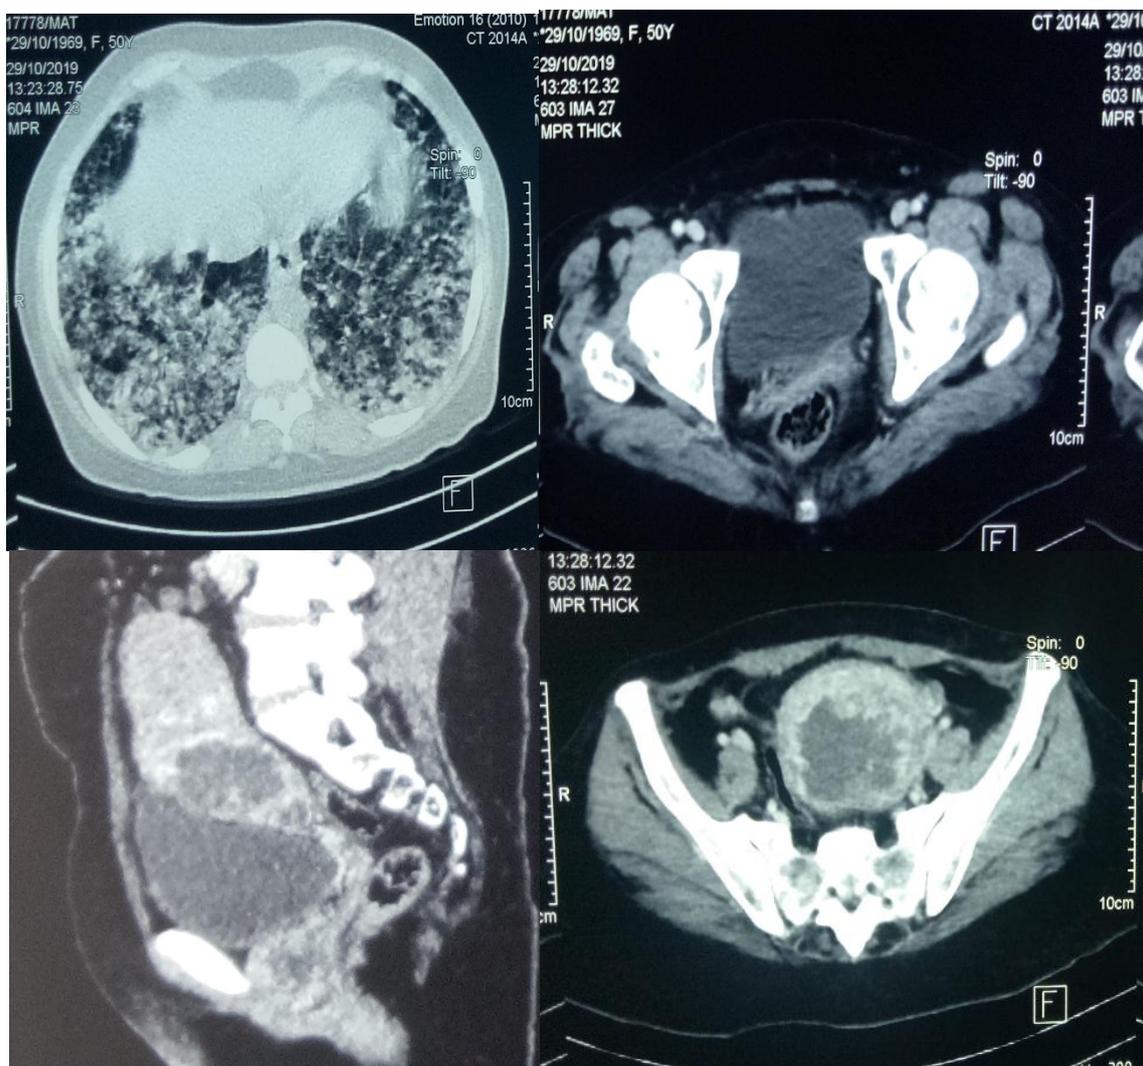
Thoraco-abdominal CT: subpleural nodules, bilateral micronodules, globular uterus closing cystic formations.
